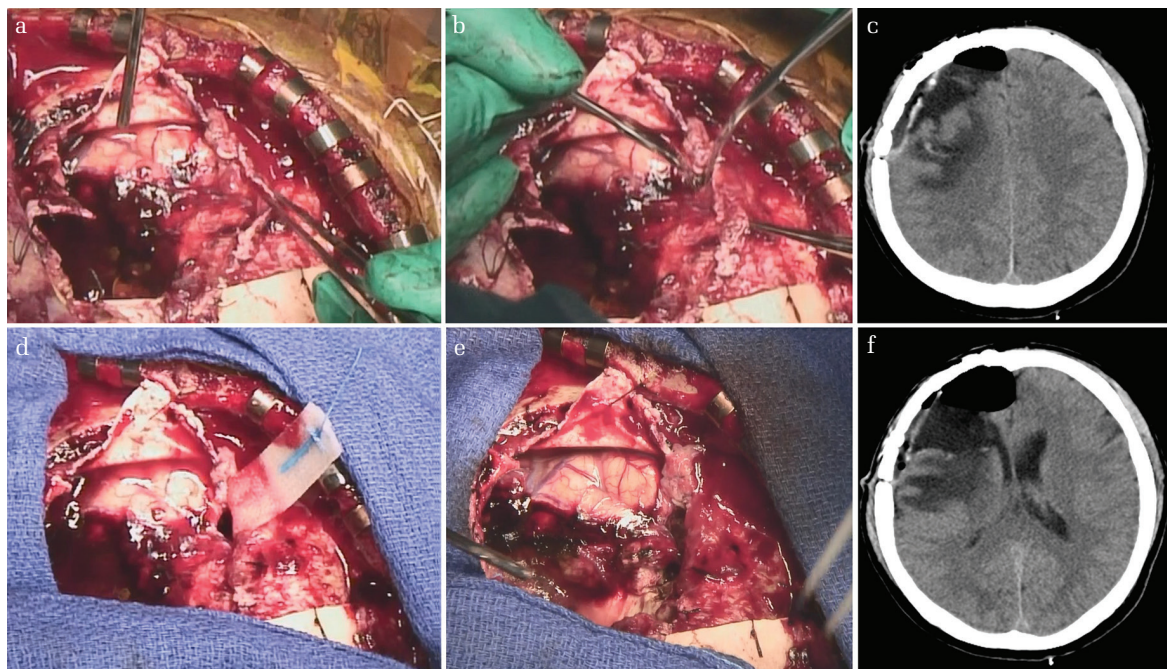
Operative findings of the cyst fenestration. Operative findings showing the cyst before opening (a and b) and after opening (d). The cyst was easily punctured (b and d). The posterior wall of the tumor resected cavity and the anterior wall of the cyst are partially removed, and the cyst and the tumor resected cavity are connected to each other (e). The left side of the images corresponds to the frontal cranial base, and the lower side of the images corresponds to the medial side of the head. CT scans the day after cyst fenestration show the disappearance of the cyst (c and f).
